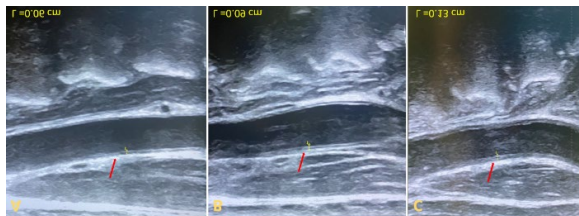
B-mode ultrasound images of the carotid artery show the two thicknesses of the deepest layers of blood arteries (the intima and media) (red arrows) in patients with non-alcoholic fatty liver disease, showing varying thicknesses. A) normal intima-media thickness in a patient with grade I fatty liver changes; B) mildly thickened intima-media in a patient with grade II fatty liver changes; and C) markedly thickened in a patient with grade III fatty liver changes.
